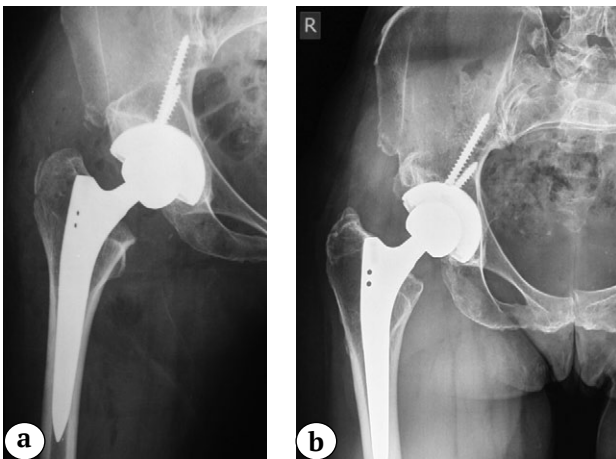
A 40-year-old patient in 2014 underwent left THA for dysplastic hip arthritis, with a canal fill index of 0.63 in the 1st zone, 0.79 in the 2nd zone, and 1.0 in the 3rd zone (a). At the time of the survey, the patient was satisfied with 10 points, and VAS pain score was 0. X-rays taken 6 years later show signs of stress shielding syndrome of the 3rd degree, characterized by thinning of the inner cortical layer below the level of the lesser trochanter (b)
